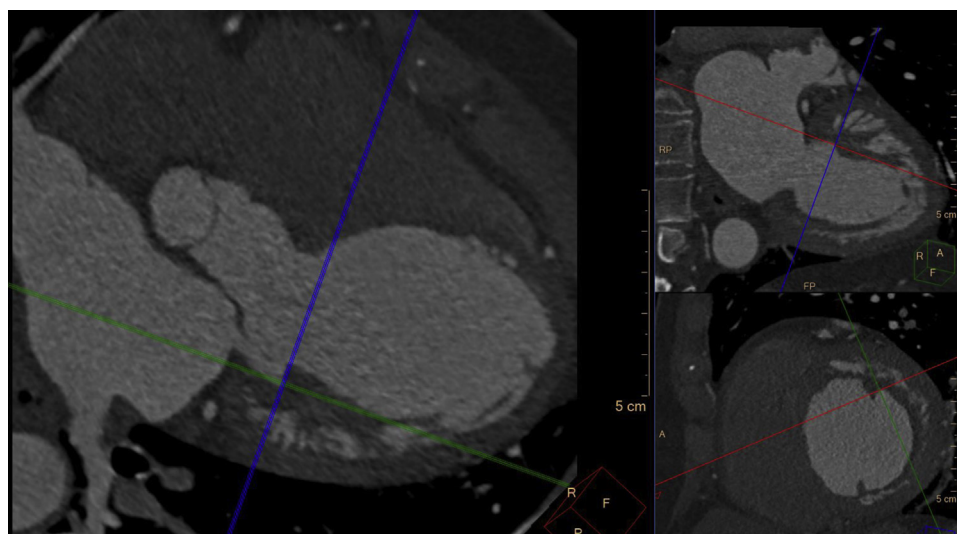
Cardiac computed tomography demonstrating non-delaminated posterior leaflet. Three projections through the left ventricle showing non-delaminated posterior leaflet with rudimentary remnants of subvalvular apparatus.
